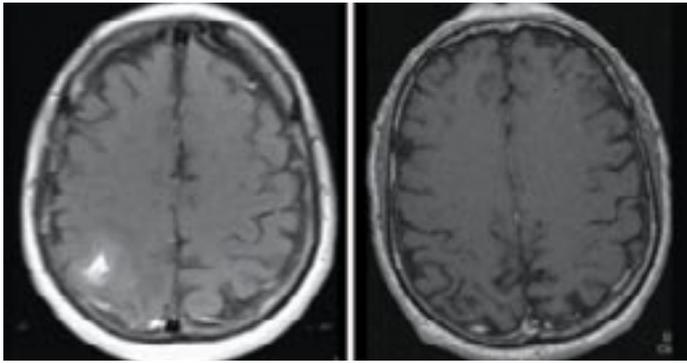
MRI brain. Panel A. An axial, post contrast-enhanced, fat-saturated T1-weighted image of the brain shows a 2.0 x 1.0 cm right parietal mass with ill-defined area of enhancement. Panel B. An axial, contrast enhanced, fat-saturated T1-weighted image of the brain, 3 weeks after therapy with cabozantinib, shows resolution of the prior mass and surrounding enhancement.
